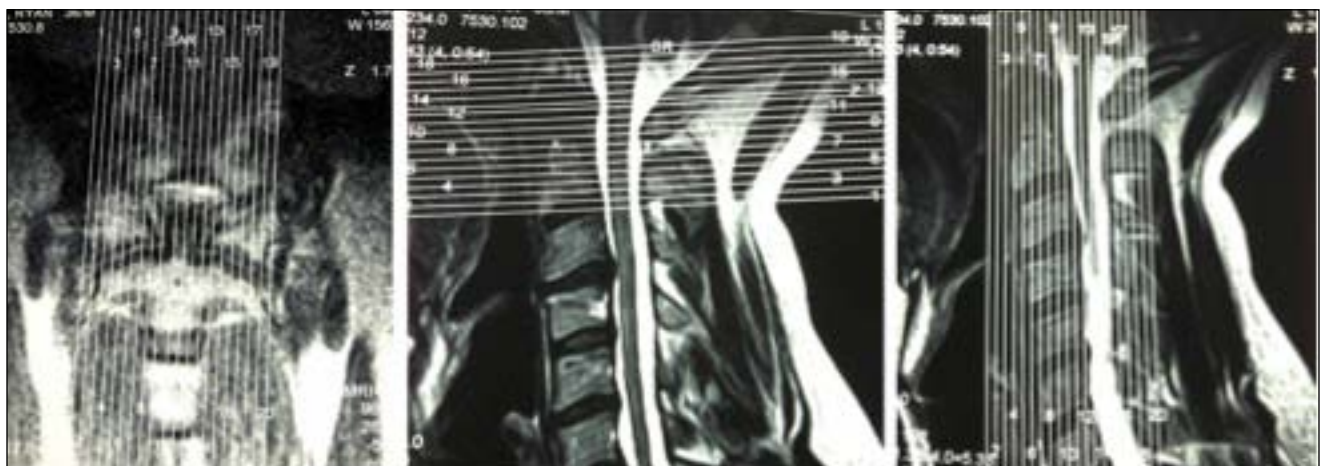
CCJ MRI Sequences in the Sagittal (left), Axial (middle) and Coronal (right) Planes
